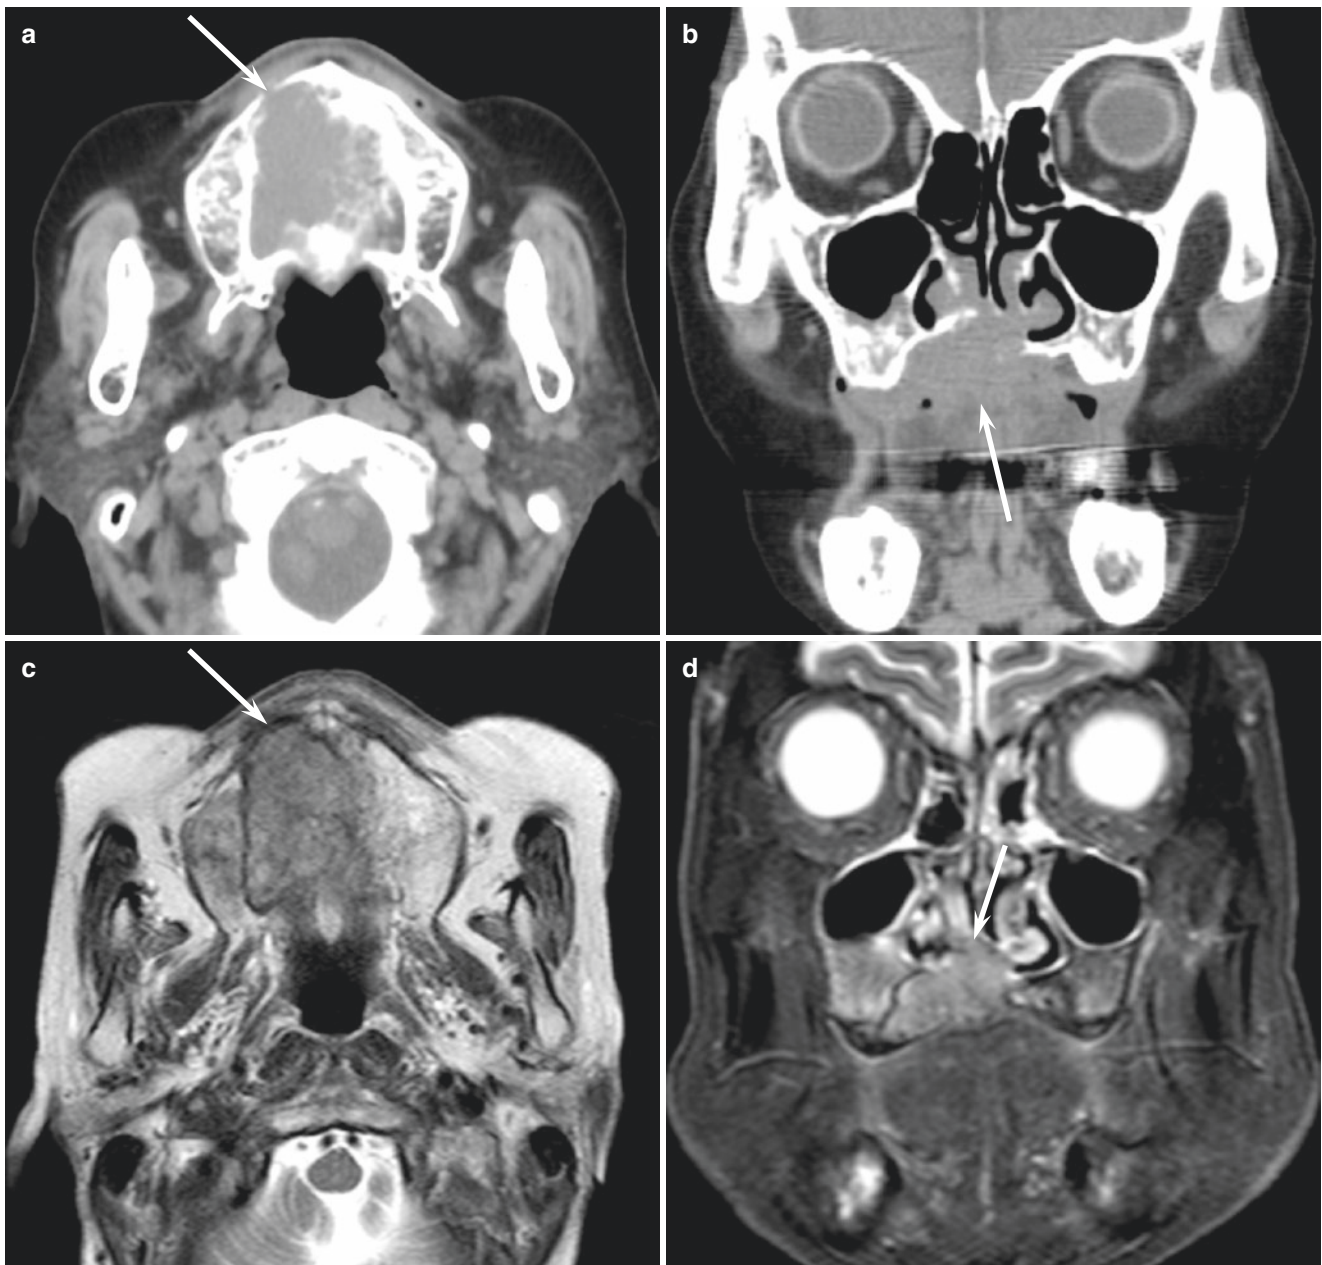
A 90-year-old woman with polymorphous adenocarcinoma of the right palate. (a, b) Unenhanced CT images show an ill-defined, invasive lesion (arrow) with destruction of palatine bone. (c)
